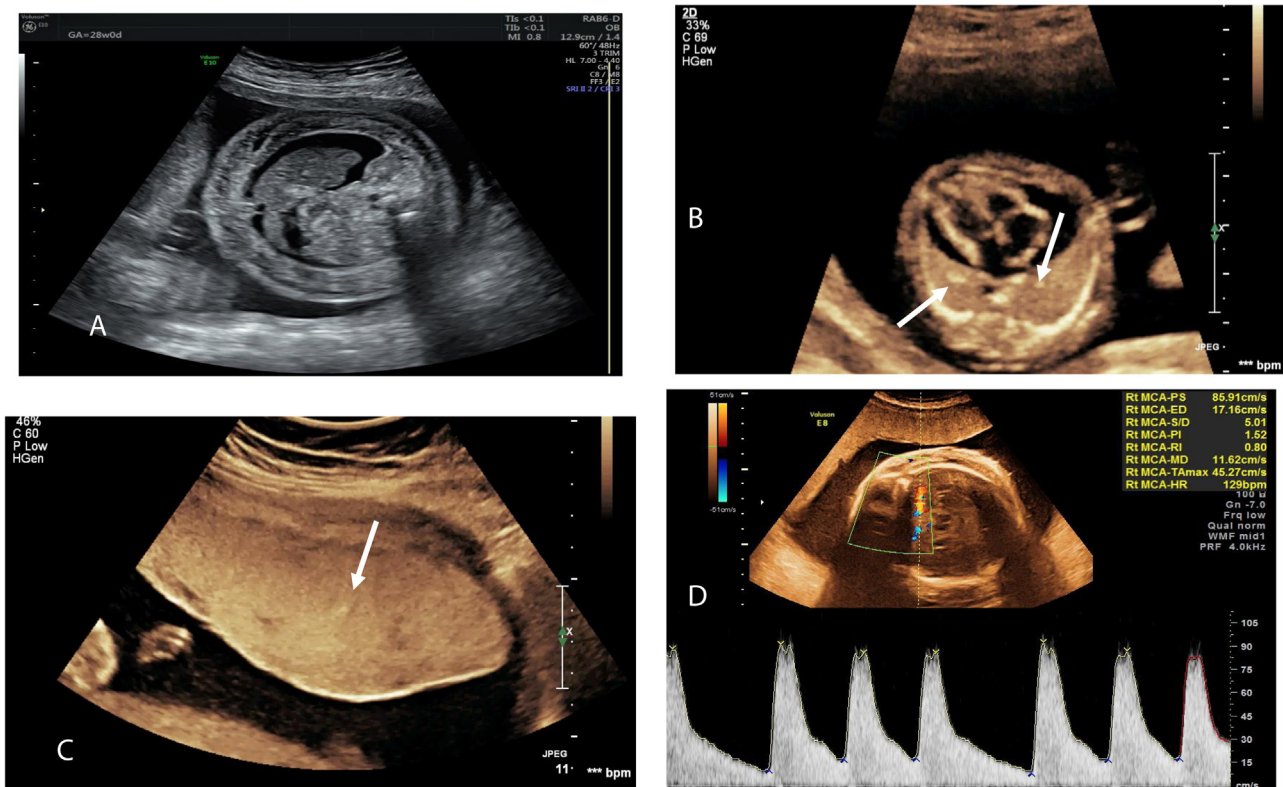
4 images of fetuses with intrauterine infection with parvovirus B-19. Fig. 3A shows a fetus with ascites and oedema around the abdomen, 3B shows a pericardial effusion and echogenic foci in the lungs (arrows) in a fetus with hydrops from Parvovirus, 3C placentomegaly with an intraplacental echogenicity (arrow) and 3D the middle cerebral artery Doppler with elevated PSV indicated of fetal anaemia.
